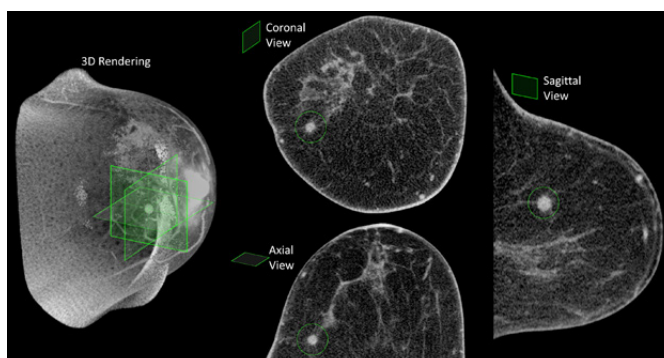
Example of a 3D breast CT image, displaying a breast tumour in the coronal, axial, and sagittal views, and in a 3D rendering of the breast.
